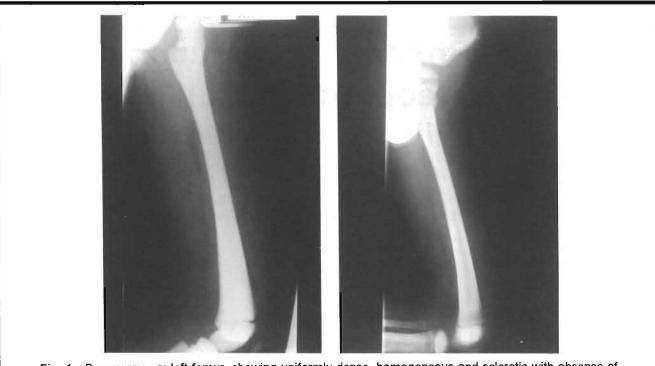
Bone x-ray. a: left femur, showing uniformly dense, homogeneous and sclerotic with absence of corticomedullary junction, b: post transplant bone x-ray left femur (day +386) showing improvement with medullary canal and distinct corticomedullary border.
